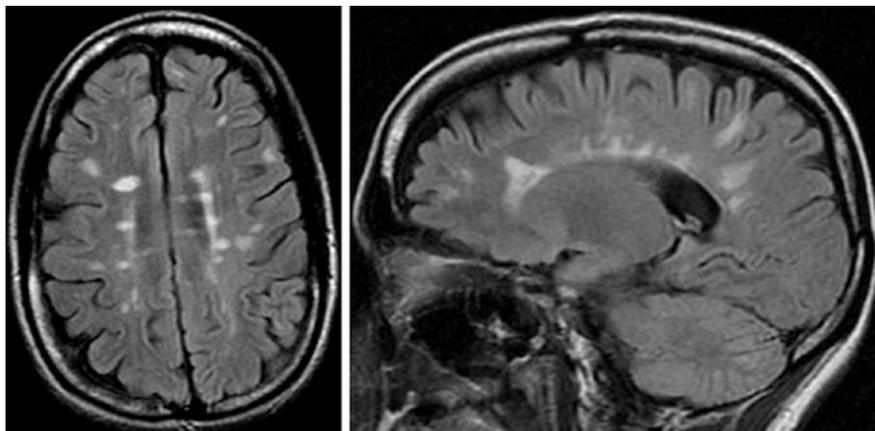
Typical MRI appearance of MS. Axial and sagittal MRI FLAIR sequences with periventricular and juxtacortical lesions, with classic Dawson's fingers (periventricular ovoid FLAIR hyperintensities radiating perpendicularly from lateral ventricles and involving the corpus callosum on sagittal MRI)
